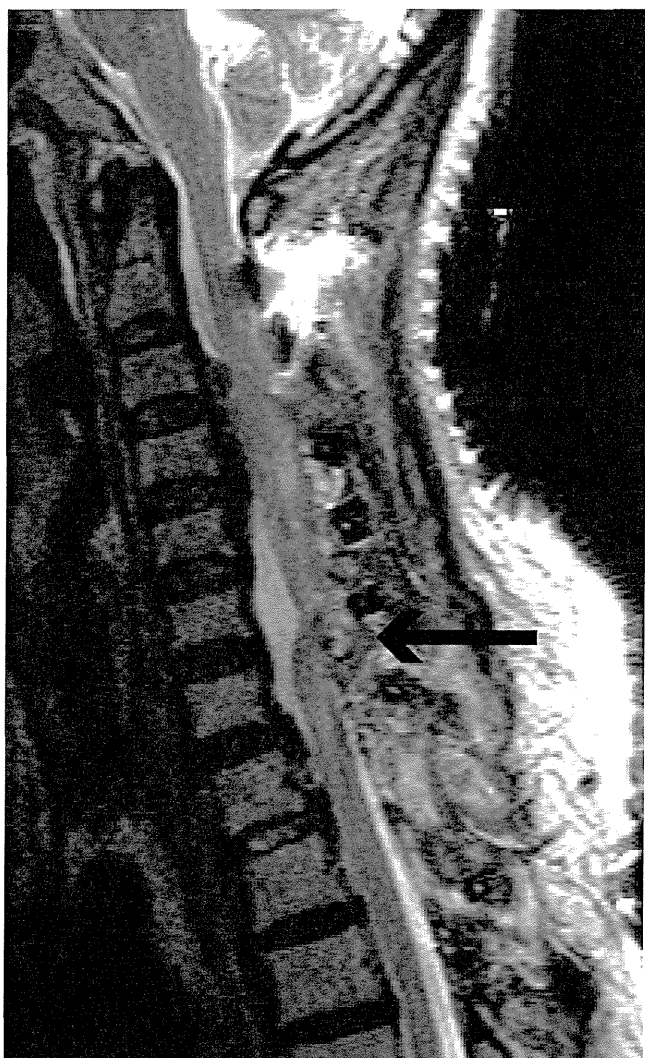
Postoperative T2-weighted imaging of a case with spinal cord herniation through injured dura mater (arrow).
